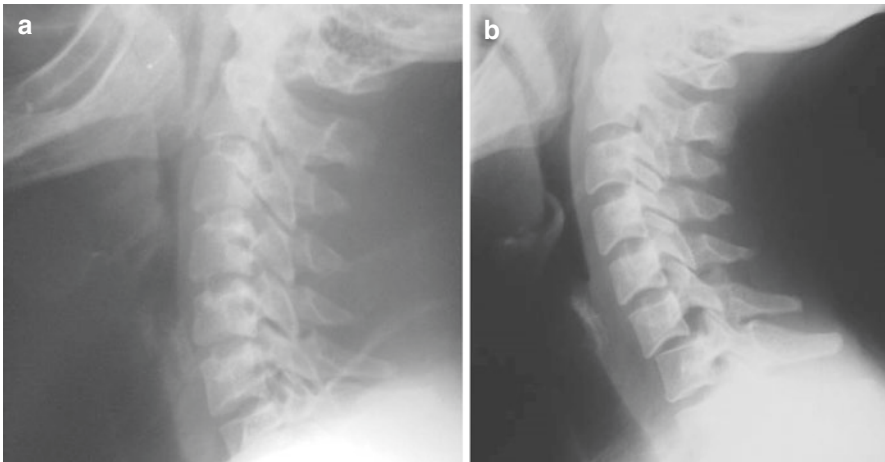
(a) Direct lateral radiogram taken in the emergency room shows normal findings; (b) C6–C7 injury seen in control X-ray taken at 2 weeks follow-up
